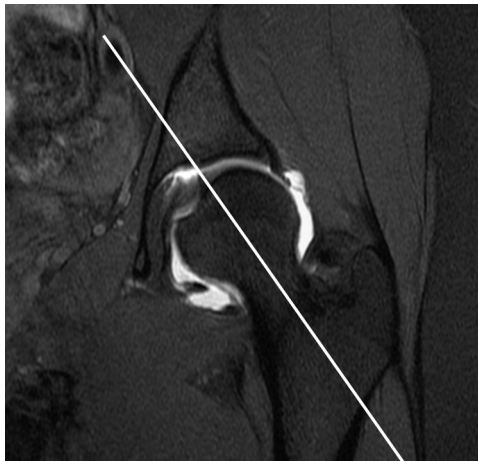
Orientation to prescribe the oblique axial sequence. Coronal T1-weighted fat-suppressed MR arthrogram image demonstrates the plane used to obtain the oblique axial sequence.
